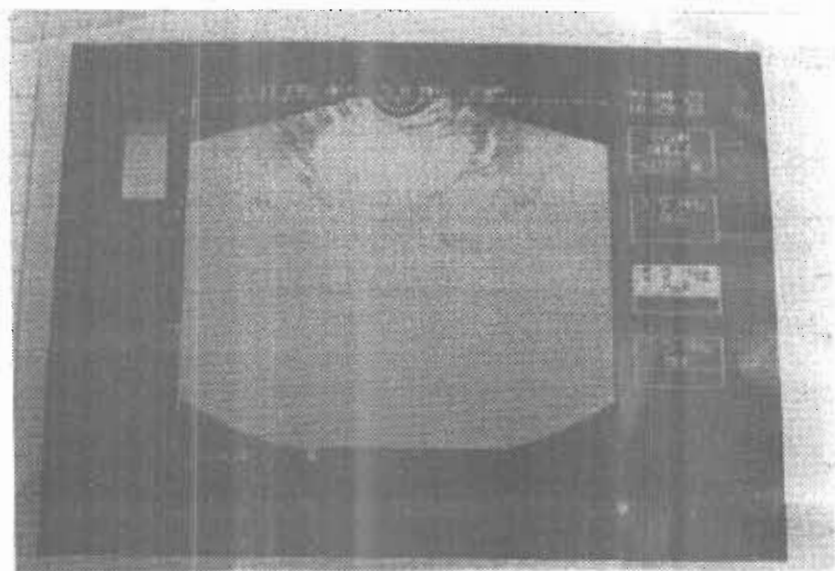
Ultrasonography of normal testis showing that the testicular parenchyma was evenly echogenic.
